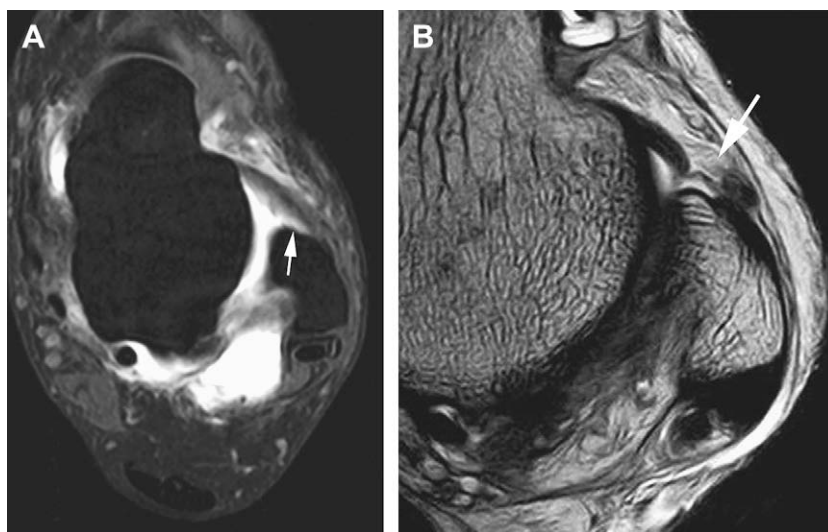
Chronic tear of the ATFL. (A) Axial fat-suppressed T1-weighted MR arthrogram image shows diffuse irregular thickening and partial detachment at peroneal insertion of the ATFL (arrow). (B) Axial T1-weighted MR arthrogram image demonstrates focal disruption of the peroneal insertion of the ATFL (arrow).
